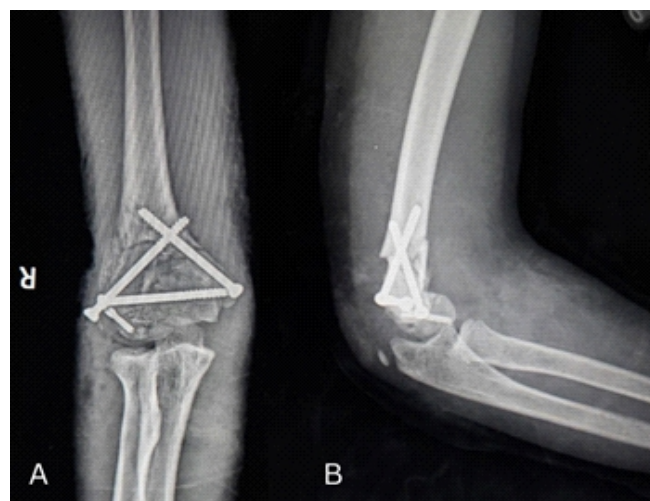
Immediate post-operative X-rays showing triangular construct CC screw fixation of distal humerus fracture with Herbert screw fixation of capitulum fragment. (a) Anteroposterior view, (b) lateral view.
